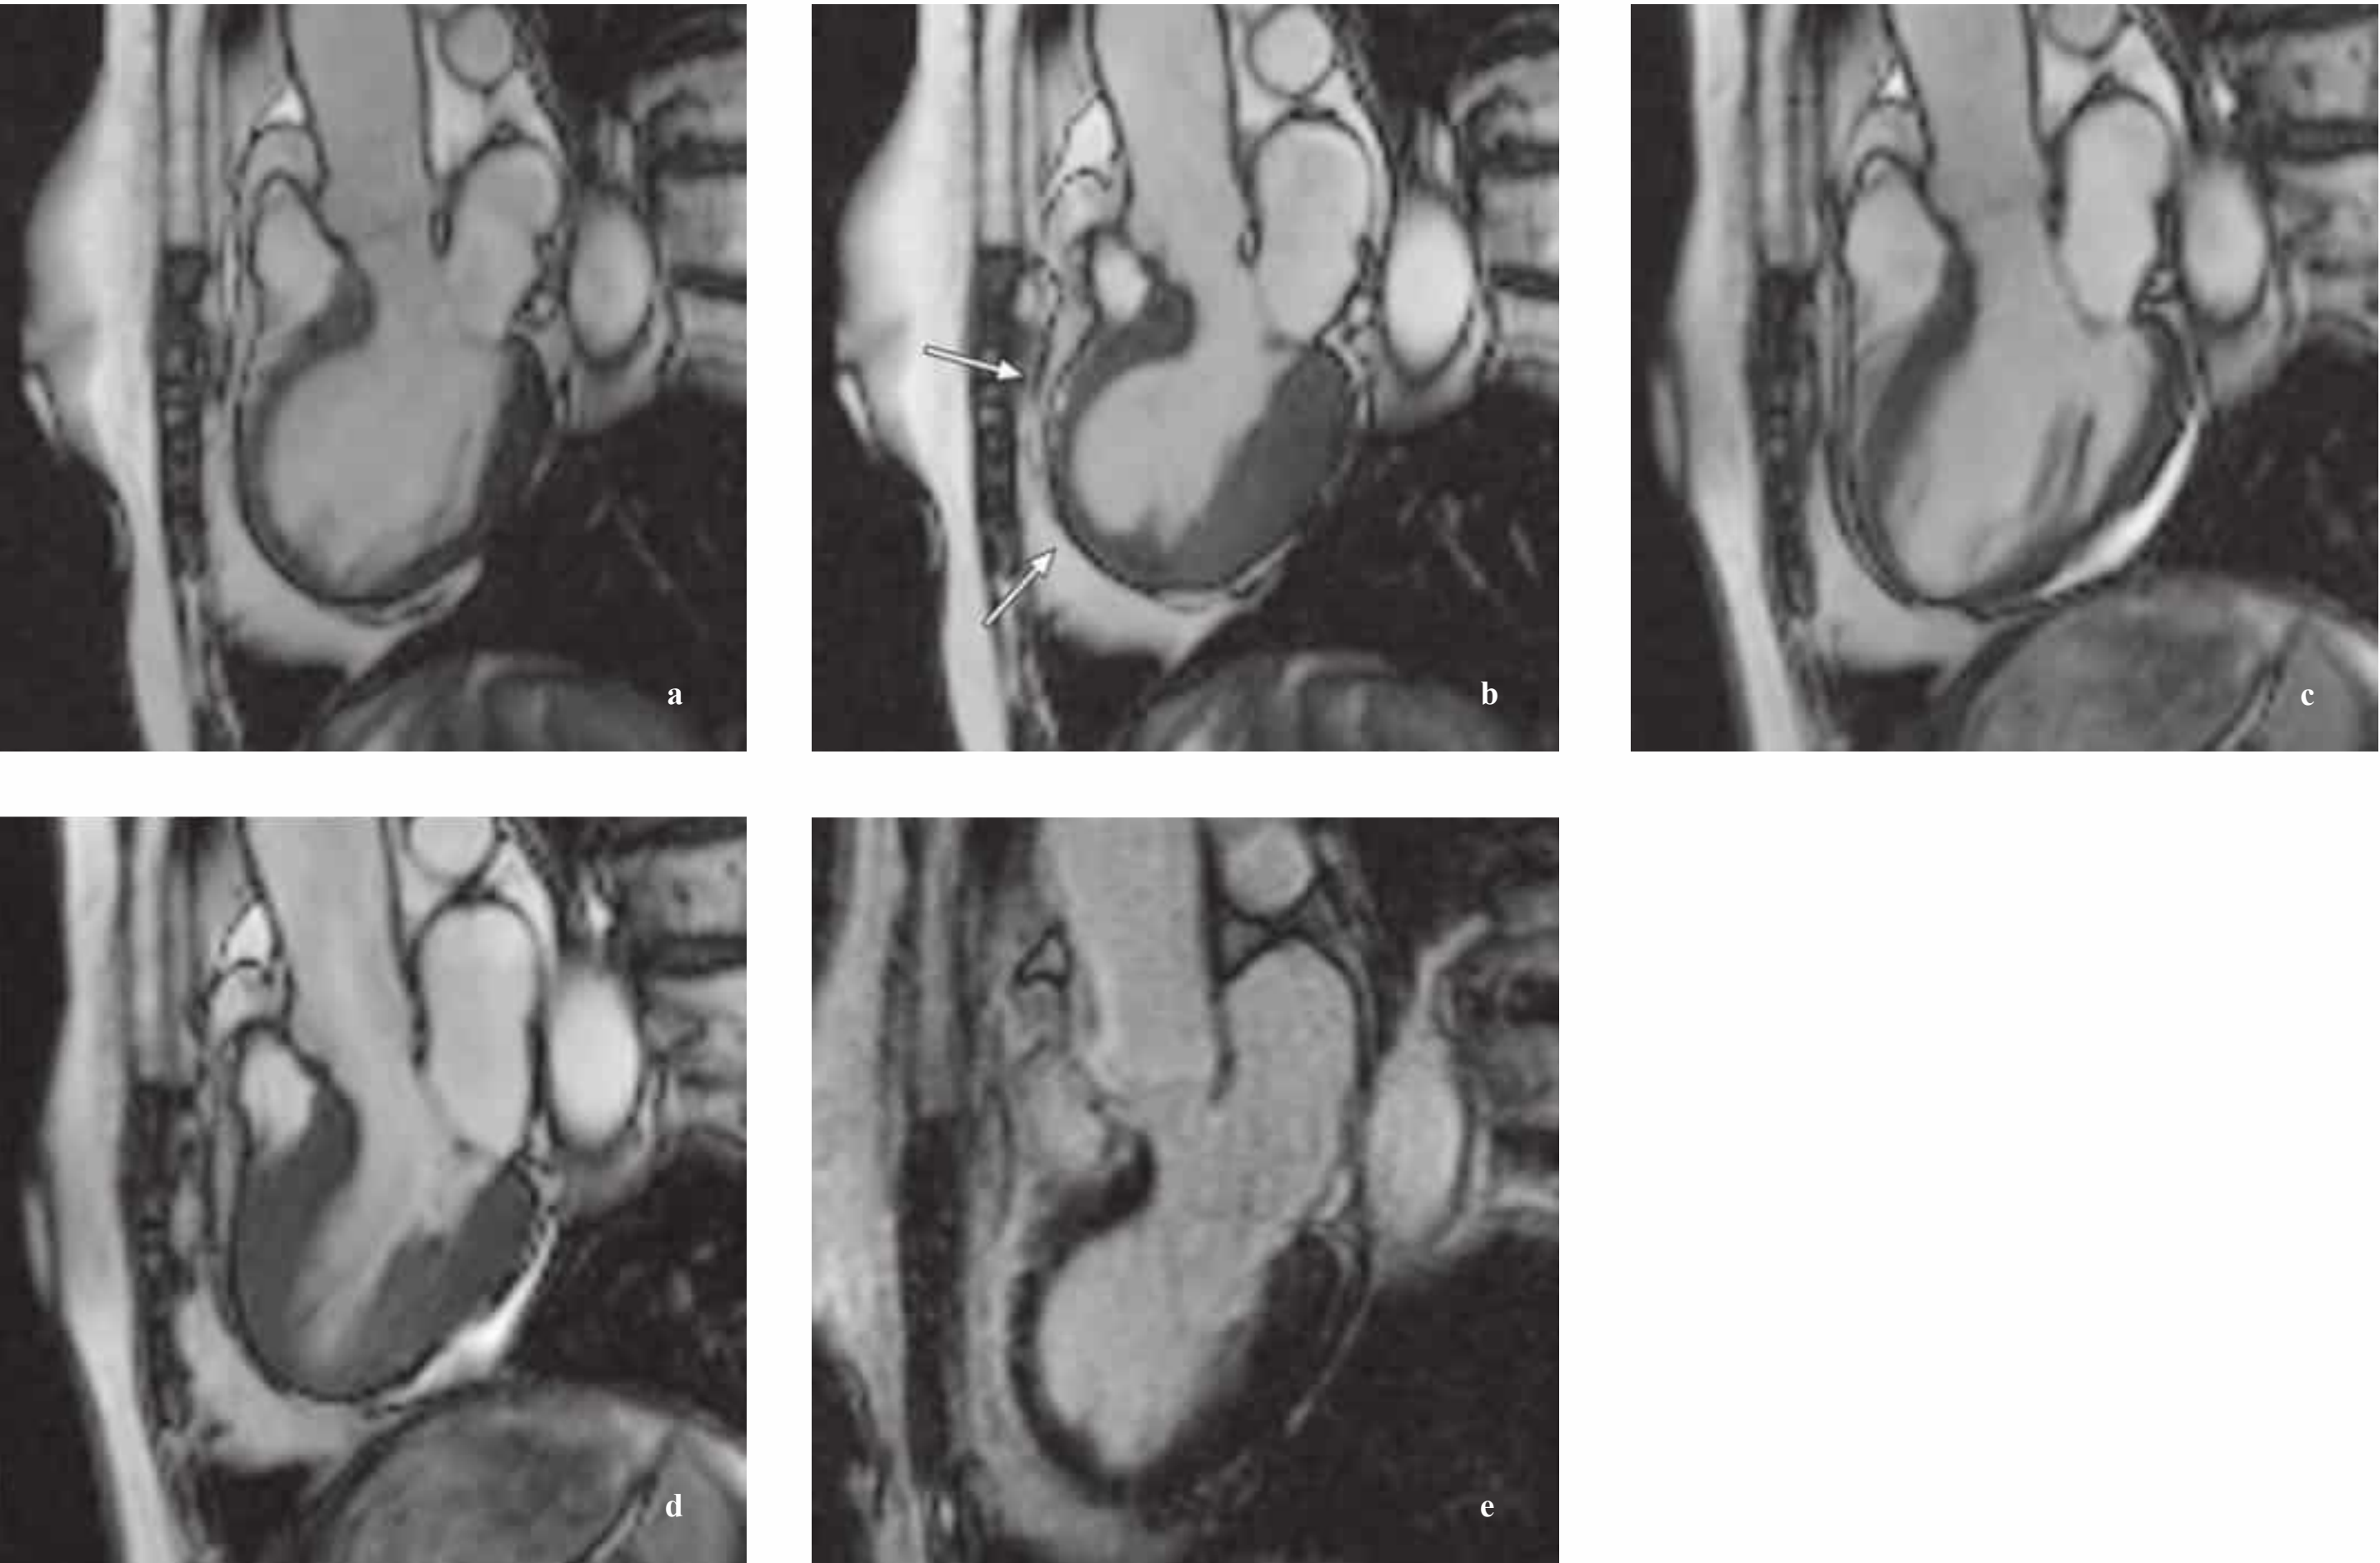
a–e A woman 70 years of age presented with typical angina pectoris and anterior ST-segment elevation typical of myocardial infarction following a dispute with her husband. Cine MRI, performed immediately after angiographic exclusion of coronary heart disease, shows extensive anterior wall dyskinesia (apical ballooning, arrows) and a marked reduction of systolic left ventricular global function. Images taken 7 days after the event document complete
